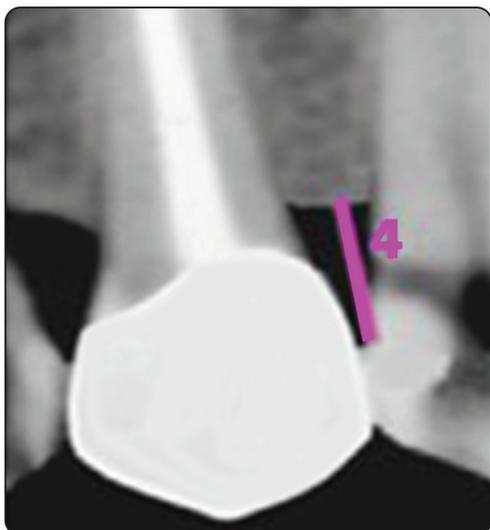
A- X-ray of second premolar with CMS crown.
